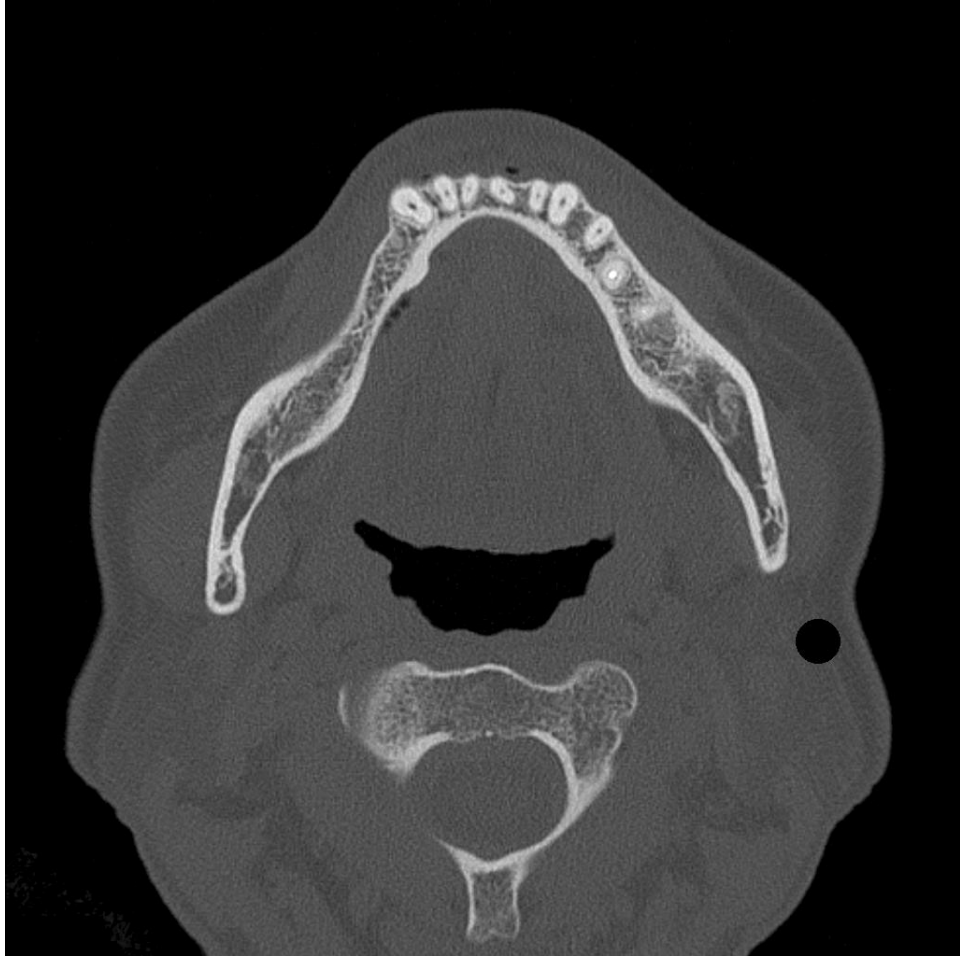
CT date (DICOM) of mandibula bone
